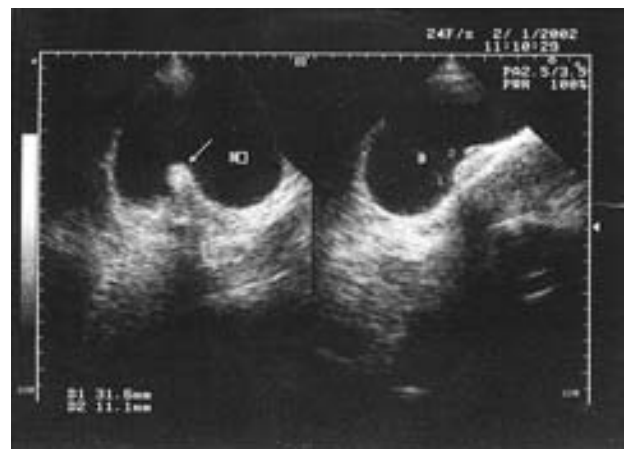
Transabdominal median longitudinal ultrasound scan of pelvis during menstruation shows conical vegetation in posterior wall of the bladder (arrow).
